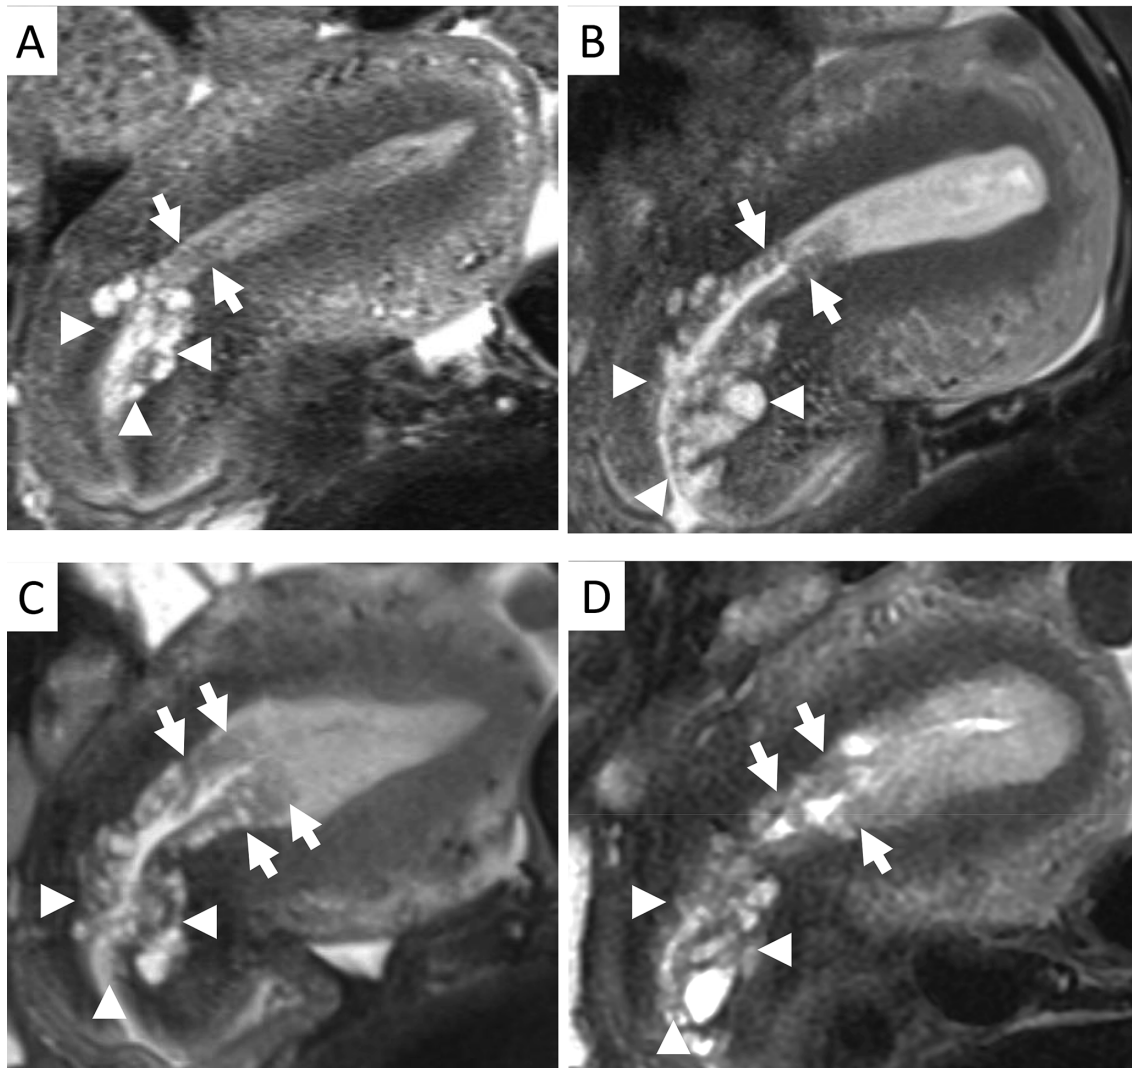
Sagittal fat-suppressed T2-weighted MR images (T2-WI) at the ages of 41 (A), 46 (B), 48 (C), and 49 years (D). Clustered small cystic lesions were observed at the inner endocervix and were surrounded by larger cysts with a clear margin in the uterine cervix (arrowheads). The low-intensity area with small cysts and continuous to CMCL on T2-WI gradually extended to the uterine endometrium and the cyst inside was also enlarged (arrows).
